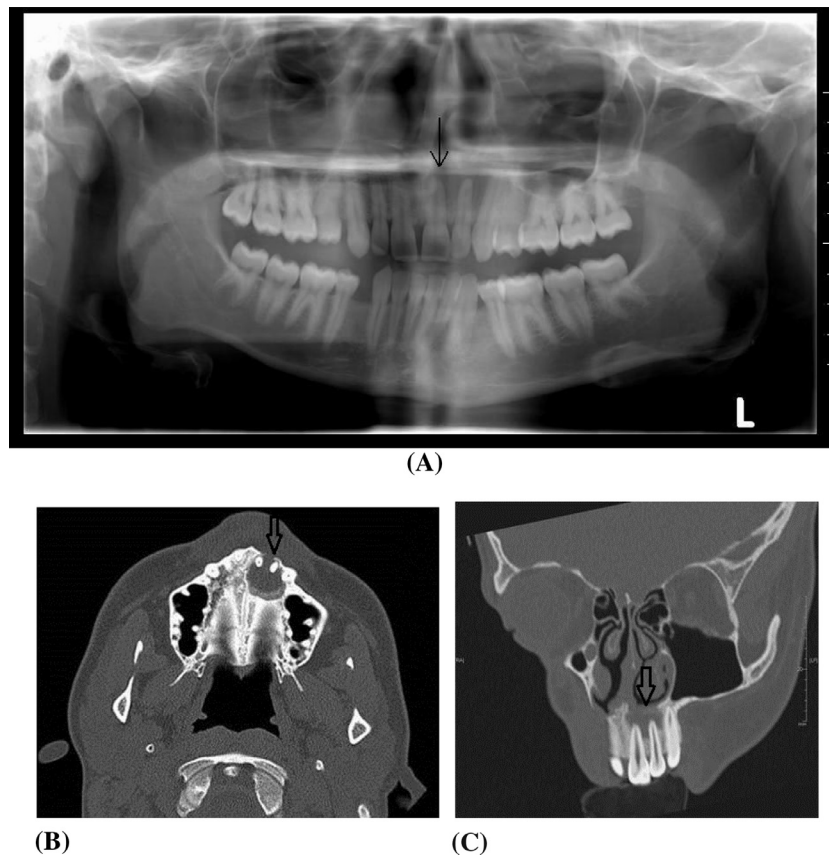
A case of periapical abscess surrounding the roots of the left maxillary medial and lateral incisors with focal bony destruction involving the left incisive bone (premaxilla) as well as the palatine process of the left maxilla resulting in oro-nasal fistula. The incisive canal is still intact. (A) Digital Panorama X-ray view: the lesion is hardly noted as faint lucency surrounding the diseased roots (arrow). (B and C) Axial and reconstructed coronal oblique MDCT images in bone windows. (D–J) The abscess and fistula are demonstrated in 3-D VR images using different angles and software. (I and J) Views from the nasal side of the fistula.
